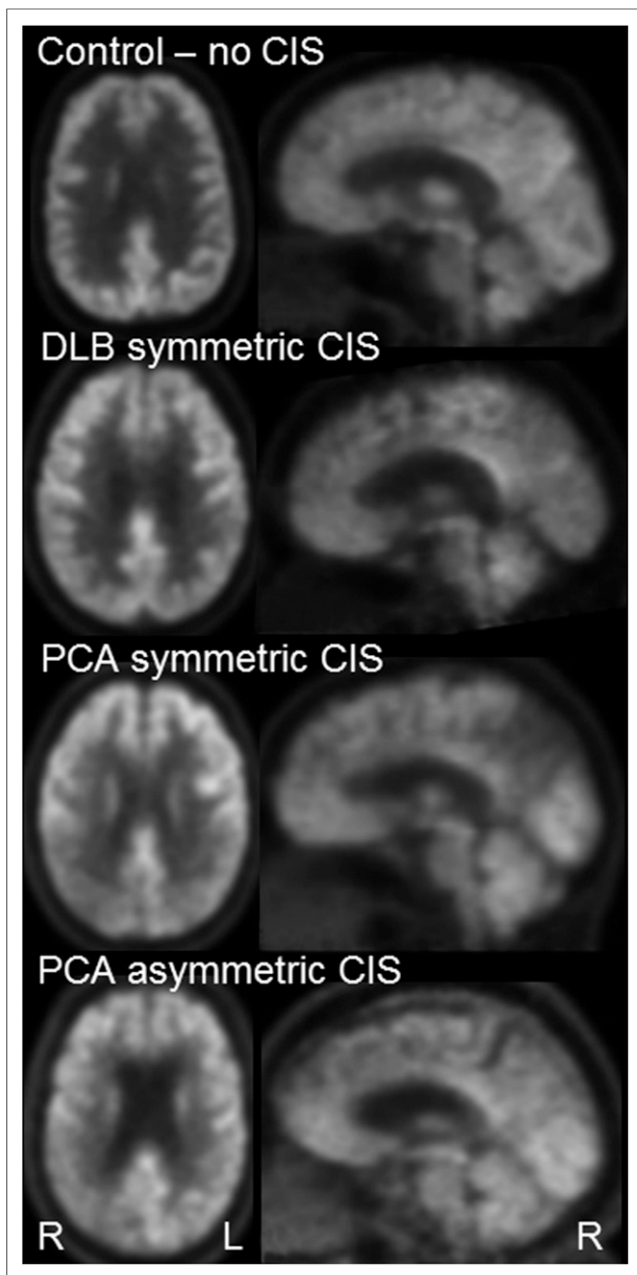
Example ^{18}F -FDG PET showing CIS in PCA and DLB.
